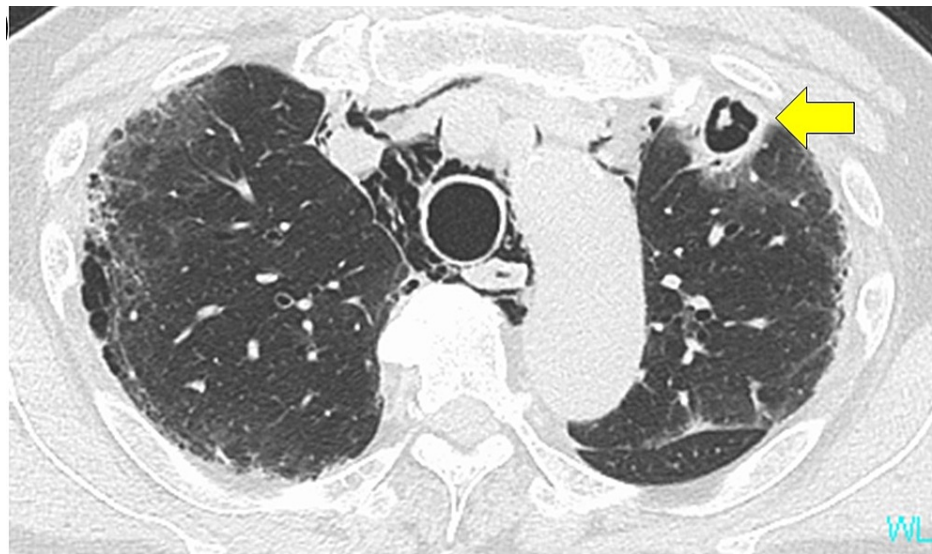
Chest CT findings on day 26
